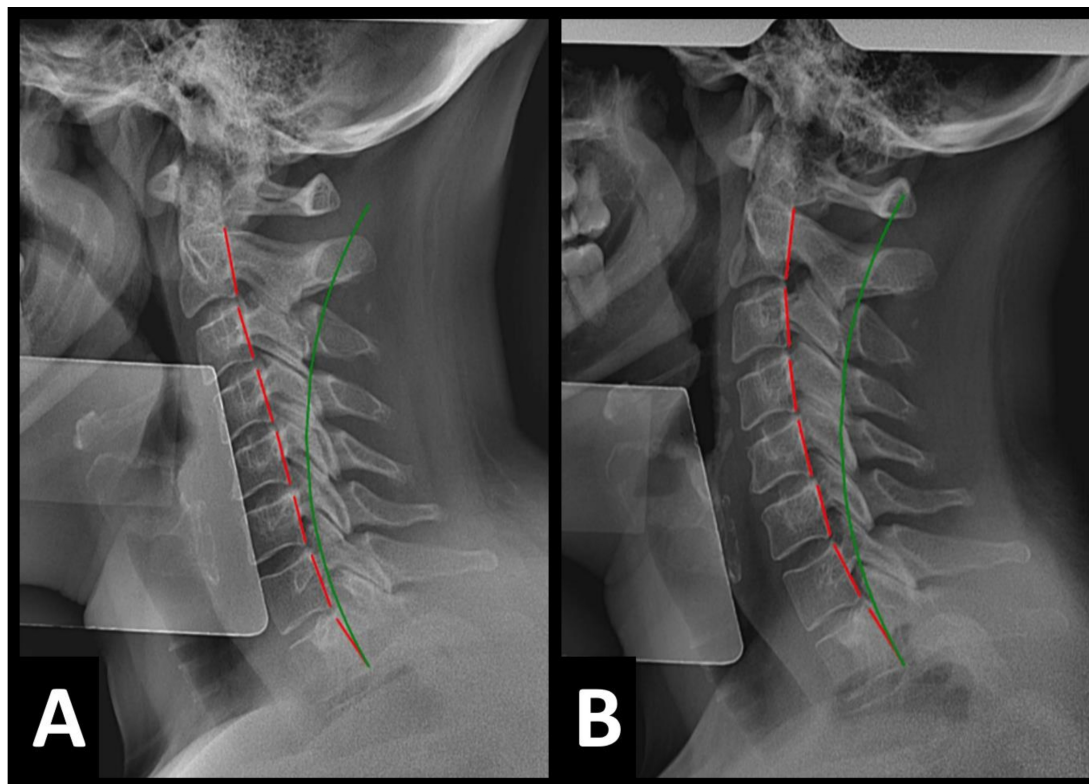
Initial and Final Neutral Lateral Cervical Radiographs Example 1
